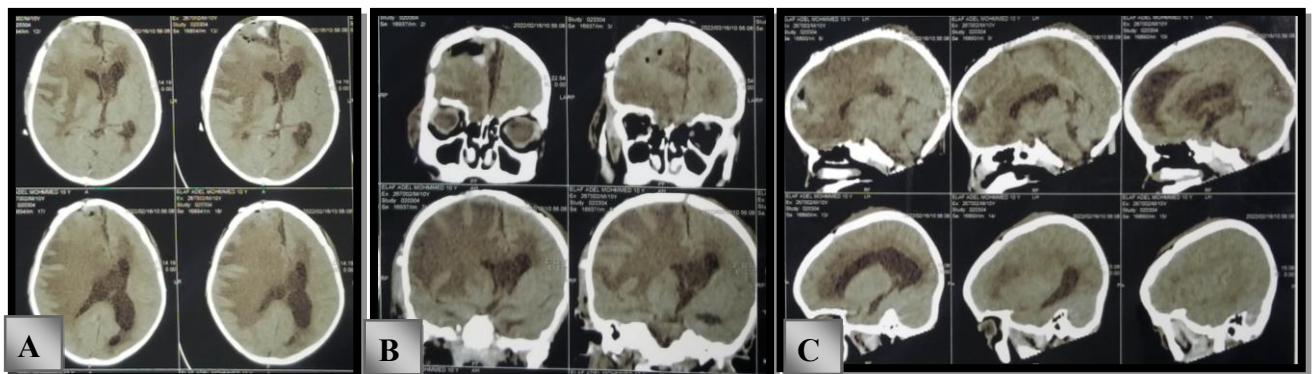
Control Brain CT scan on Day 1 post-operation. A: Axial cut, B: Coronal cut, C: Sagittal cut.
